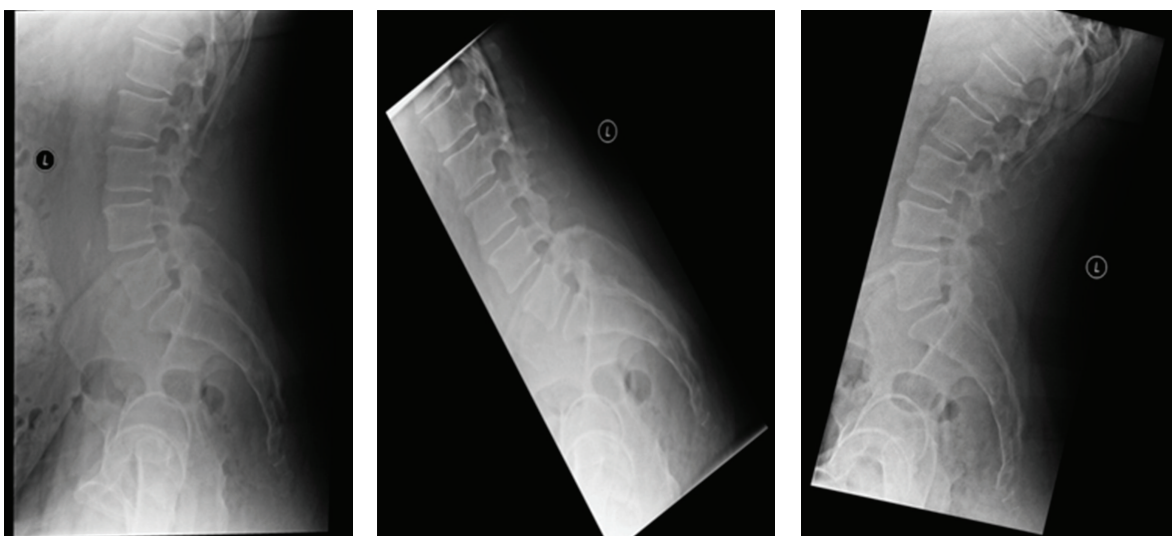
This patient's X-rays, including the upright lateral flexion and extension, are overall unremarkable.
